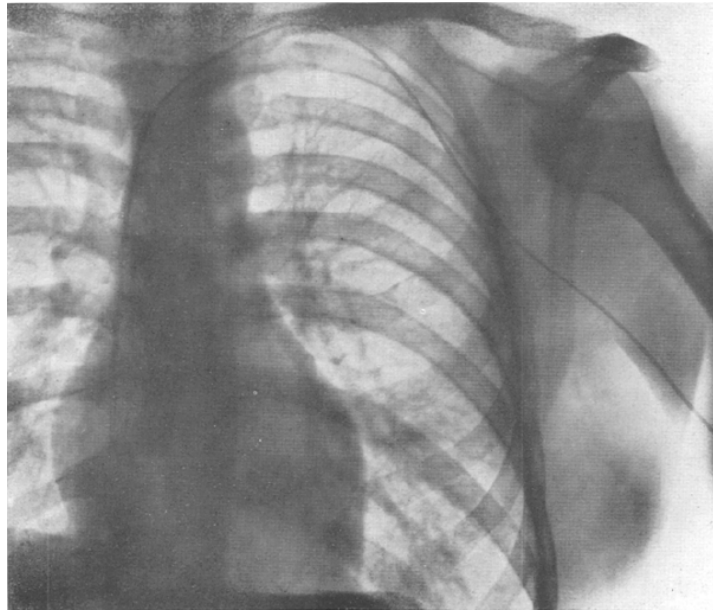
Dr. Werner Forssmann's pioneering catheter insertion into the right atrium. This historical x-ray image captures the first human cardiac catheterization performed by Dr. Forssmann on himself, demonstrating the catheter's path from his left arm into the heart.
